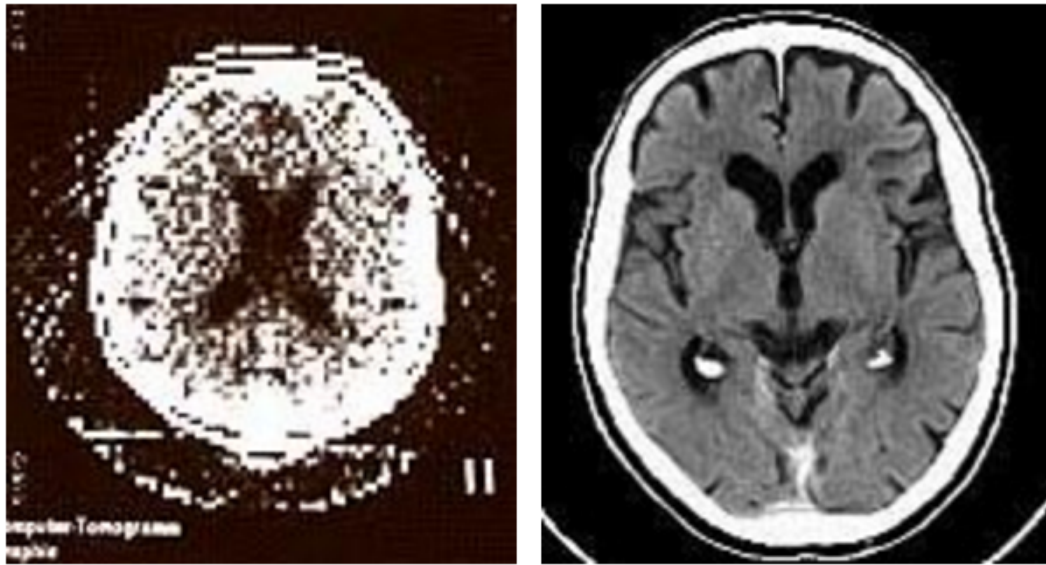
Left: Circa 1975, early days of the CT scanning. Right: Current CT imaging of the brain. The two images demonstrate how much image quality has progressed over the last 4 decades (*Siemens Circa 1975 n.d.*).
